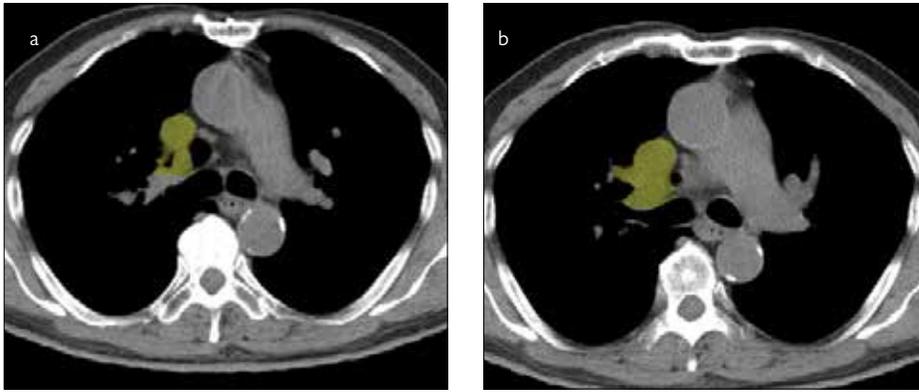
a, b. Computed tomographic (CT) scan showing the existence of abnormal vessels of the right upper lung lobe that communicate with the superior vena cava
